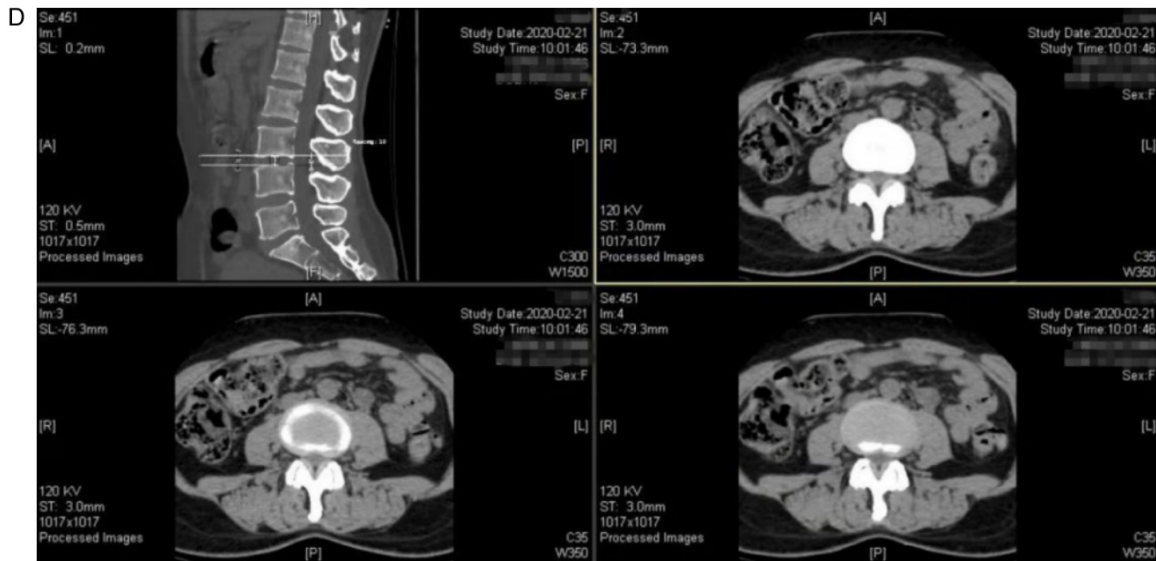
CT images before and after treatment. Compared with before treatment (A, B), lumbar curvature was slightly increased, and L3/4 disc herniation was slightly improved after treatment (C, D).
